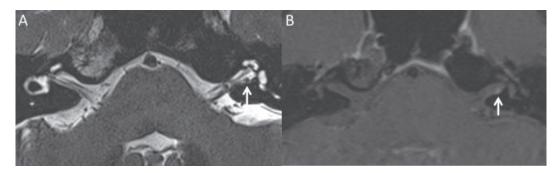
Intracanalicular schwannoma in a patient with left sensorineural hearing loss. Axial T2-weighted magnetic resonance image (MRI) of the internal auditory canal (A) showed a small rounded lesion along the left inferior vestibular nerve. Diagnosis of intracanalicular schwannoma was made in the subsequent contrast-enhanced MRI in T1-weighted sequence as the lesion demonstrated enhancement (B).
